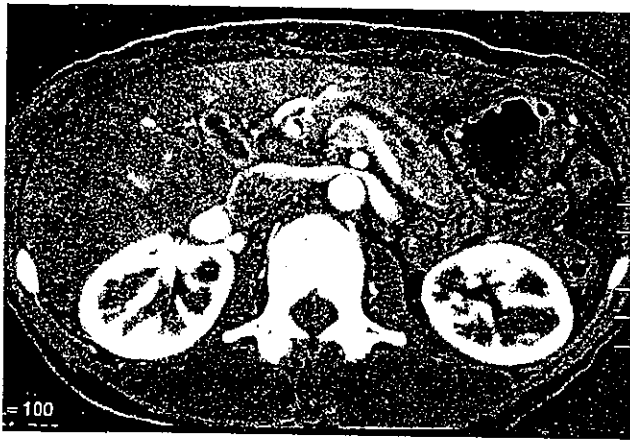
Computed tomography in the patient shows a pancreatic head mass, 3 cm in diameter
